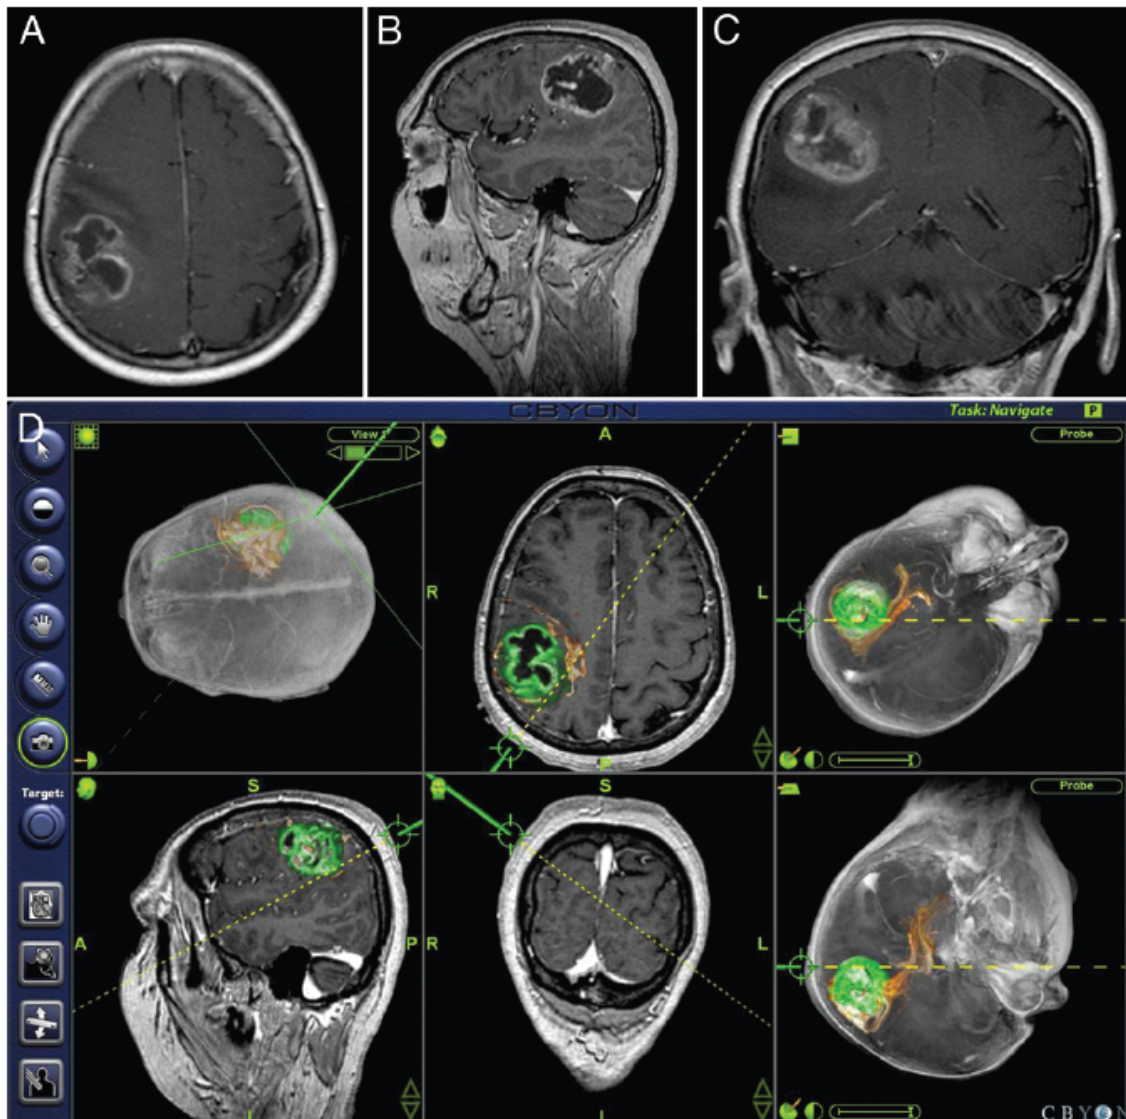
Preoperative (A–C) and intraoperative neuronavigation (D) MR images obtained in a 67-year-old woman by using the CBYON neuronavigation system (Med-Surgical Services, Inc.), showing segmented tumor tissue (green) and motor fiber tracts (orange). These images show a right postcentral glioblastoma (32.2 cm<sup>3</sup>) displacing the central gyrus and pyramidal tracts anteriorly. Presenting symptoms on admission were weakness of the left arm and disturbed fine motor skills of the left hand.
